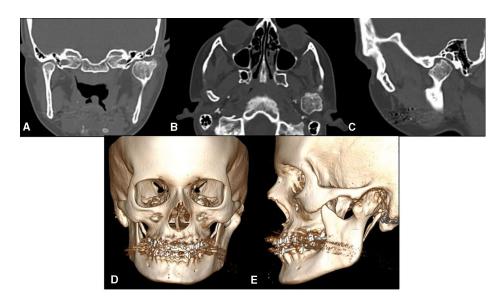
CT scans showing a well-delimited hyperdense lesion involving the left mandible, with its altered morphology. (A) Coronal cut; (B) axial cut; (C) sagittal cut (D) 3D reconstruction frontal view; (E) 3D reconstruction left lateral view. [Colour figure can be viewed at wileyonlinelibrary.com]
